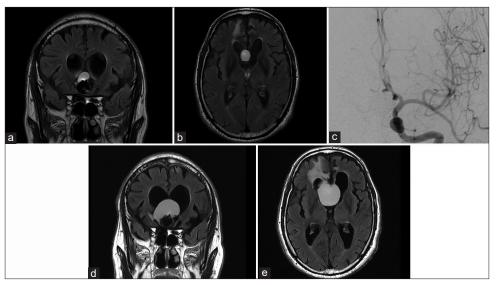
(a and b) Magnetic resonance image (MRI) 24 months after the initial treatment shows that the cystic lesion developed from just above the coiled aneurysm (a and b). (c) Cerebral angiography reveals that there is no blood flow into the perianeurysmal cyst and no recurrence of cerebral aneurysm. (d and e) MRI just before endoscopic treatment shows that an enlarged perianeurysmal cyst led to obstructive hydrocephalus and progressive parenchymal edema.
